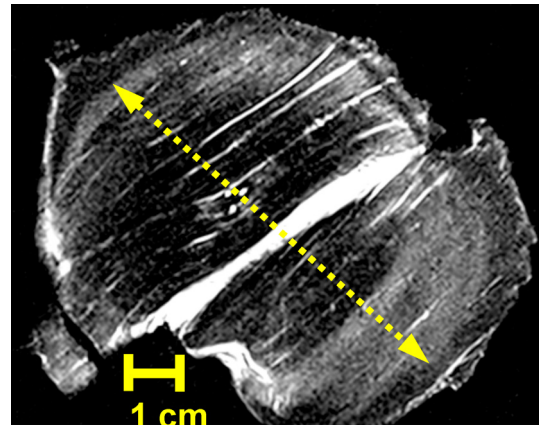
MR image of ablation zone orthogonal to electrode axis. Location of three-electrode array insertion is visible at the center as three white dots. Dotted arrow represents maximum transverse ablation zone diameter (8.2 cm in this case), and is measured at the boundary of the hyperintense (i.e., bright) rim.
